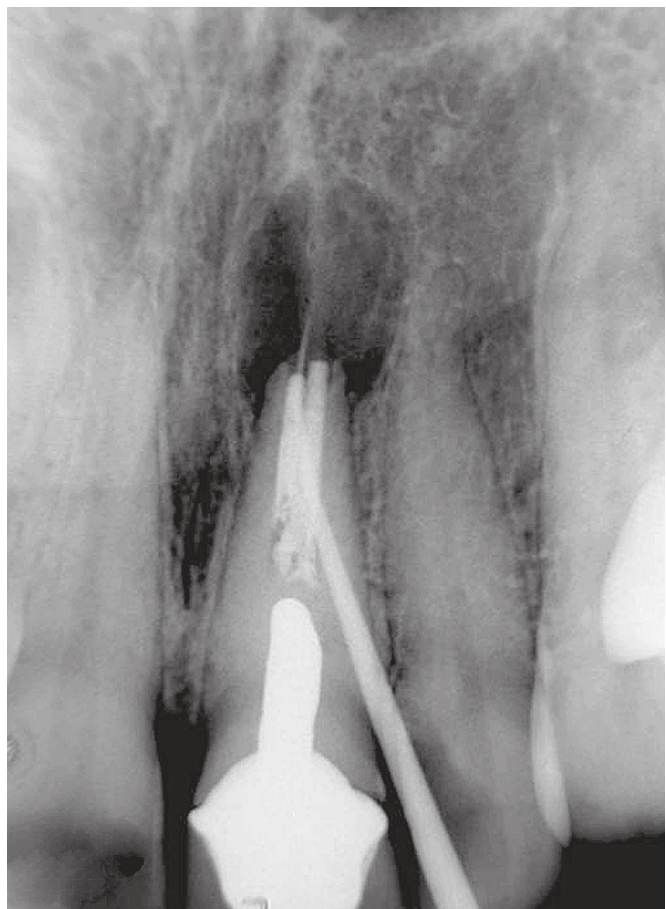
Preoperative and screening periapical radiograph.
